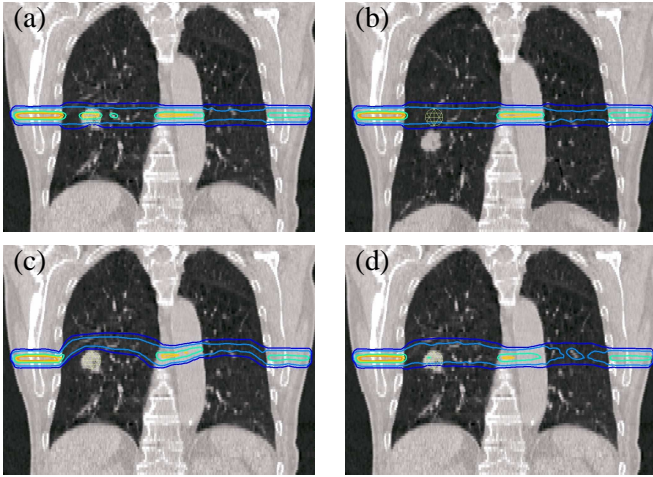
Beamlet warping: (a)/(b) beamlet doses calculated in the exhale/inhale CT. (c) beamlet dose of inhale CT warped to exhale reference geometry; (d) beamlet dose as accumulated using all 8 CTs.
